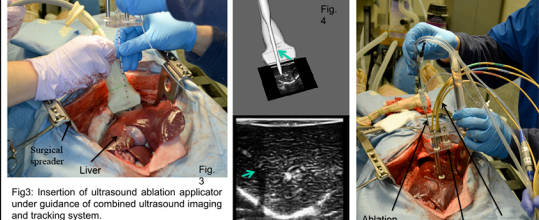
Insertion of ultrasound ablation applicator under guidance of combined ultrasound imaging and tracking system. Fig 4: Ultrasound imaging and applicator position in 2D and 3D plane corresponding to the setup shown in Fig. 3. (Arrows indicate the catheter in the 3D view and shadow by the catheter in the B-mode image). Fig 5: Treatment setup.
